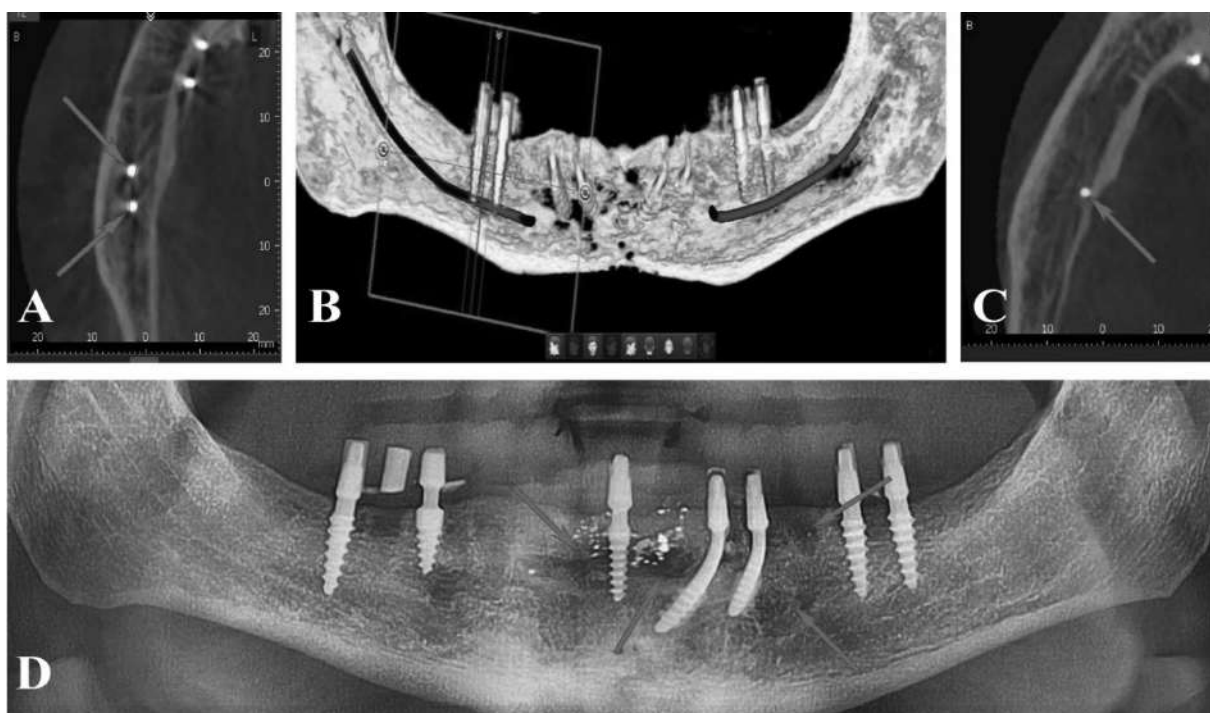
CT image of the lower jaw (LJ) presented on coronal (B) and axillary (a – right side, C – left side) sections in the format of 3D reconstruction models with the reflection of iatrogenic effects on the morphological structures of the mandibular canal; D) pathological foci with different degrees of bone destruction (panoramic radiography after removal of implants on the right side)
